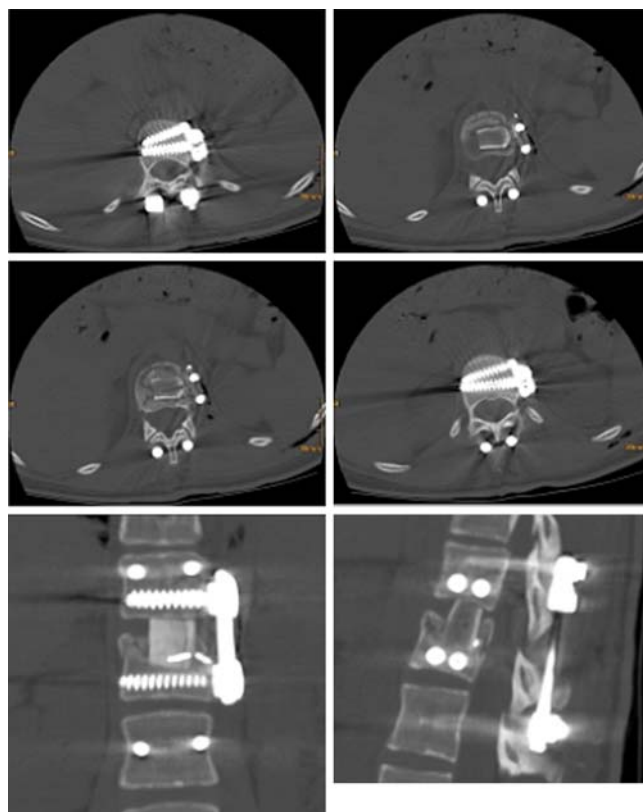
Transversal CT layers showing the bicortical screw fixation of the caudal section of Th 12, position check of tricortical iliac crest graft and two-dimensional reconstruction to check position after monosegmental stabilisation Th 11-12
